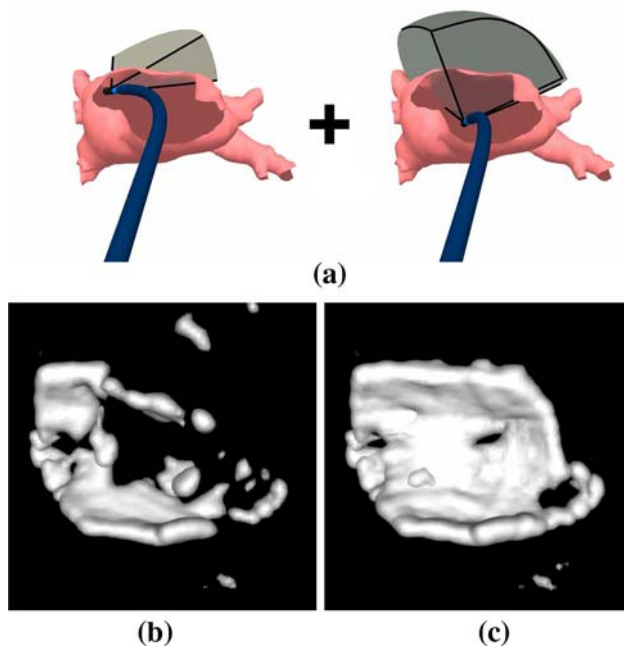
Left atrium roof imaging. We image the left atrium roof using a combination of the two configurations shown in a. The first configuration yields poor ultrasound reflections that suffer from dropout, while the second configuration yields much stronger reflections. When using WAC compounding alone b, a portion of the roof is missing from the resulting 3D-ICE volume because the dropout data negates contributions from reflections indicating tissue presence. When using WAC compounding with RGC c, however, dropout data is held separate on the basis of scan-line incidence angle, and contributions from strong reflections persist
